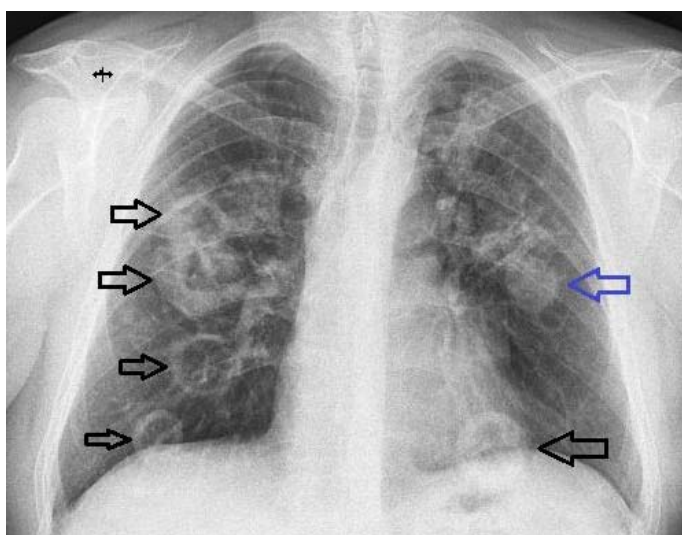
Chest X-ray PA - Nodular opacities (blue arrows), some with a tendency to cavitation (black arrows), diffusely distributed bilaterally
